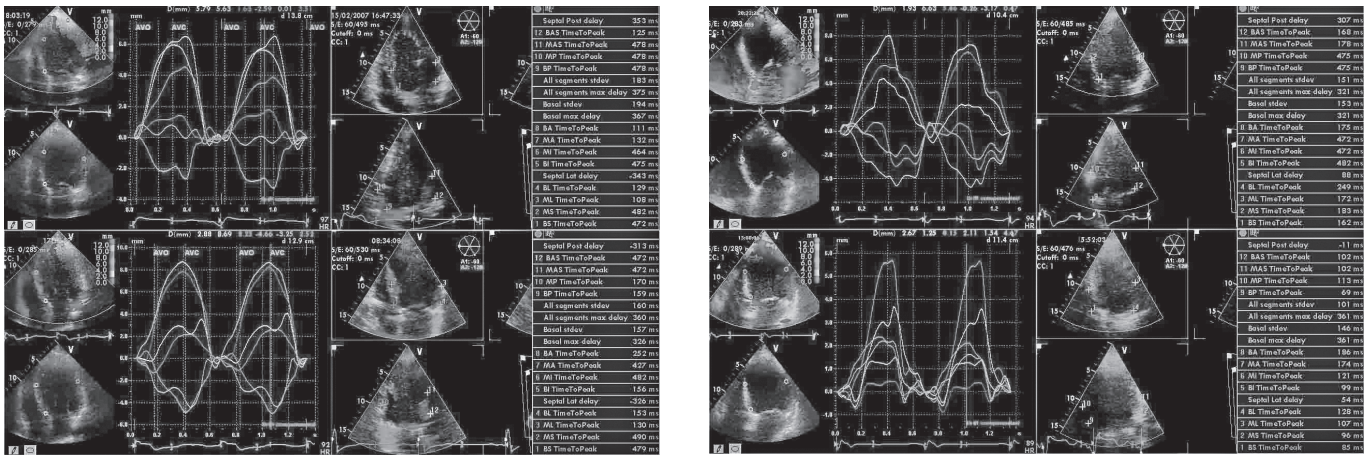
A, Example of Doppler echocardiography data obtained with tissue tracking and tissue synchronization imaging (TSI) methods in a CABG patient before (upper half) and 18 months after (lower half) the surgery. B, Example of Doppler echocardiography data obtained with tissue tracking and TSI methods in a patient in the CABG plus CRT group before (upper half) and 18 months after (lower half) the surgery.
